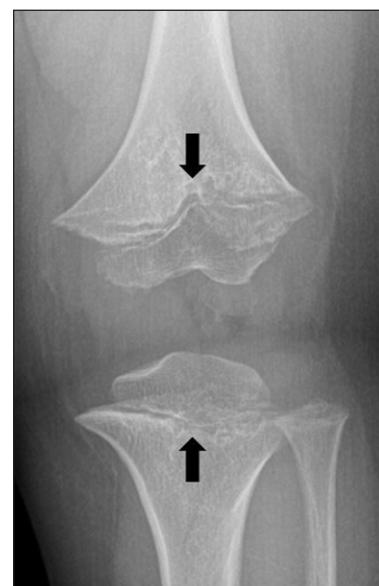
Chevron logo in achondroplasia. Plain radiograph of the right knee showing central depression of the metaphysis of the distal femur and the proximal tibia with focal protrusion of the adjacent epiphysis (black arrows). This resembles the Chevron logo sign.
